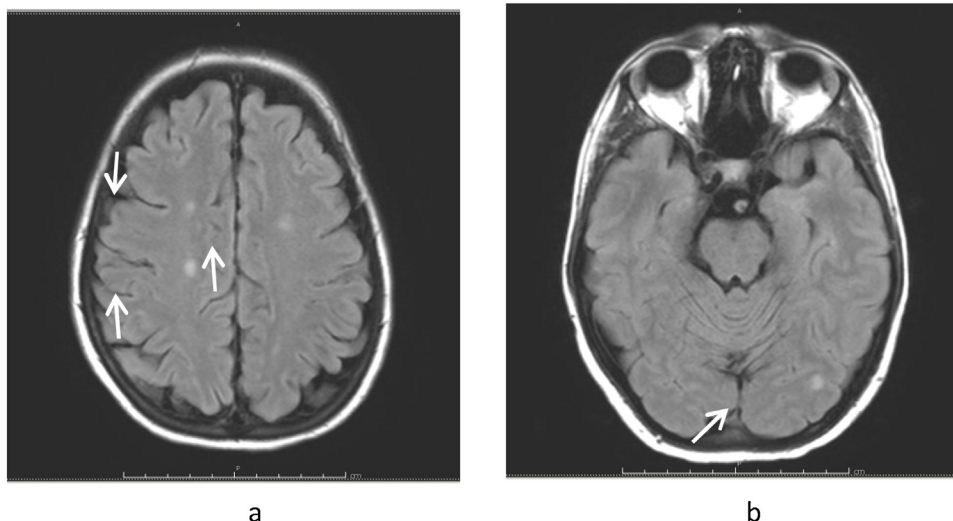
a) MRI of the brain axial view showing lesions in the bilateral frontoparietal regions. b) MRI of the brain axial view showing a lesion in the left occipital lobe.
